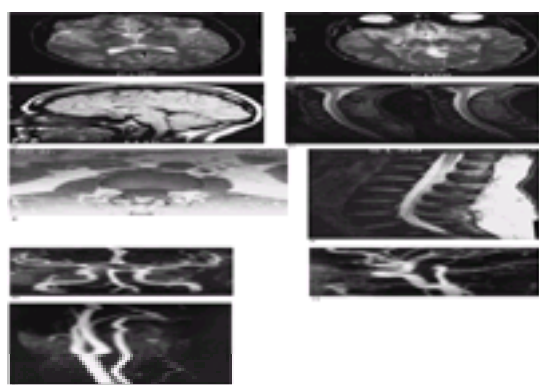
Normal MRI of the brain and the cervical and lumbar spine. A. $T2$ -weighted (SE 2500/90) axial image of the brain. White matter appears brighter than gray matter. The CSF within the lateral ventricles is very bright. The corpus callosum, internal capsule, while the globus pallidus is darker. B. $T2$ -weighted (SE 2500/90) axial image at the level of the internal capsule. The CSF within the lateral ventricles and subarachnoid space is very bright. C. $T1$ -weighted (SE 2500/90) axial image of the brain. White matter appears brighter than gray matter and the corpus callosum is well defined. Subcutaneous fat and the cervicomedullary junction are well delineated, and the region of the pituitary gland is normally demonstrated. D. $T2$ -weighted (SE 2500/90) sagittal image of the cervical spine. Note the bright signal intensity of the CSF, which provides a “myelographic” effect. Intervertebral discs demonstrate intermediate signal intensity, and the craniocervical junction is clearly defined. E. $T1$ -weighted (SE 2500/90) sagittal image of the lumbar spine. Note that bone marrow appears brighter than disc material. The neural foramina are filled with fat. F. Gradient-echo sagittal image of the lumbar spine. Note the bright signal intensity of the CSF within the thecal sac and the facet joints are well seen.
